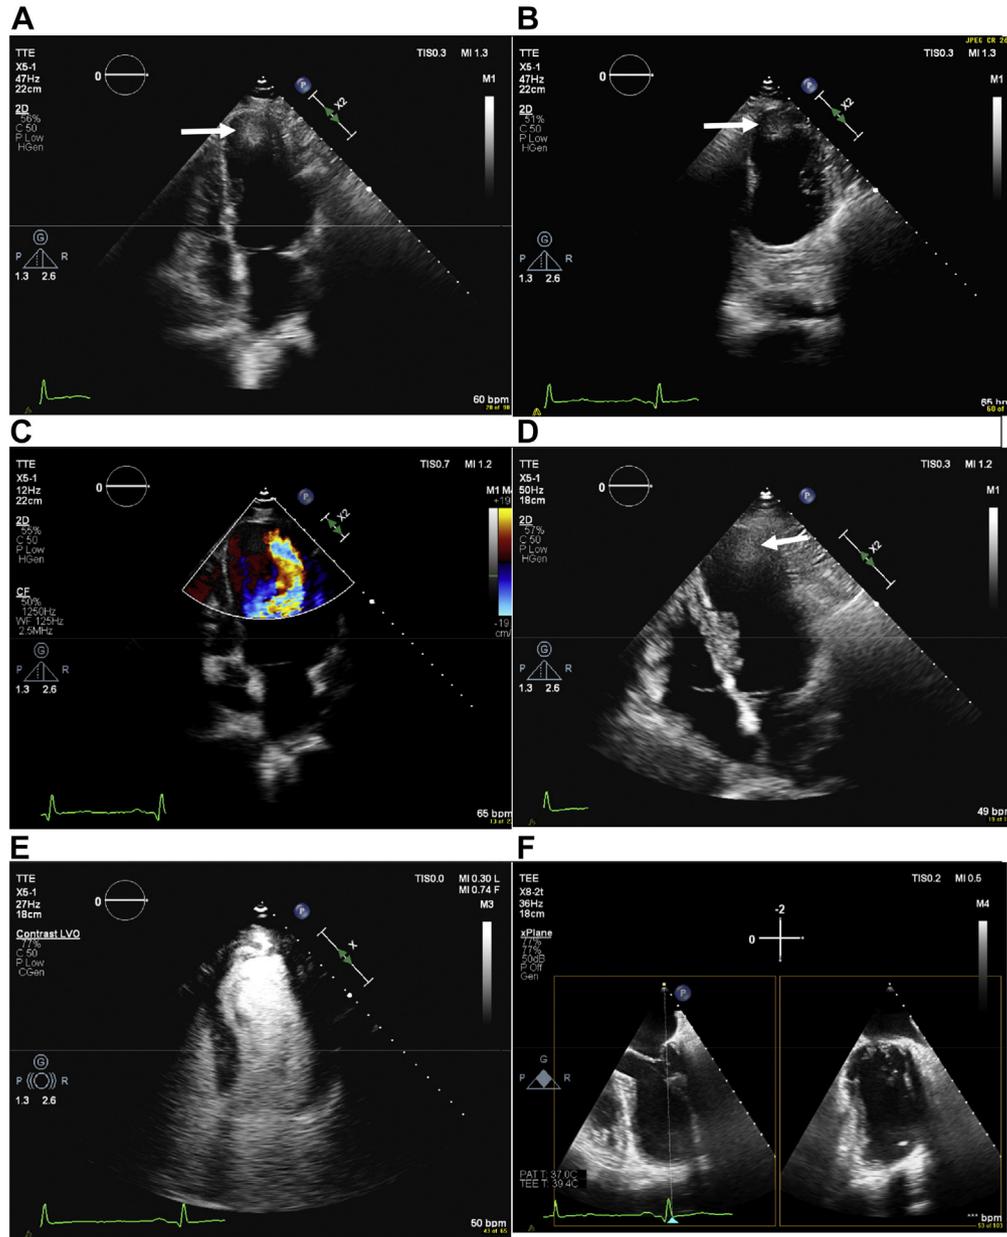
(A, B) Apical biplane four- and two-chamber views show a remarkable but poorly defined mass in the akinetic apex of the left ventricle (arrow). (C) Color Doppler imaging could not detect blood flow passing over or through the “mass,” even at low pulse repetition frequency (Nyquist limit 19.3 cm/sec). (D) When repositioning the transthoracic probe to a more apicolateral position, the apparent mass co-translocates along with the incident ultrasound beam towards the apicolateral region (arrow). The original apical “mass” cannot be observed anymore. (E) Apical four-chamber view with ultrasound contrast (SonoVue). There is complete opacification of the apex, thereby excluding an intra-apical thrombus. (F) Biplane midesophageal four- and two-chamber views show absence of an apical mass.
